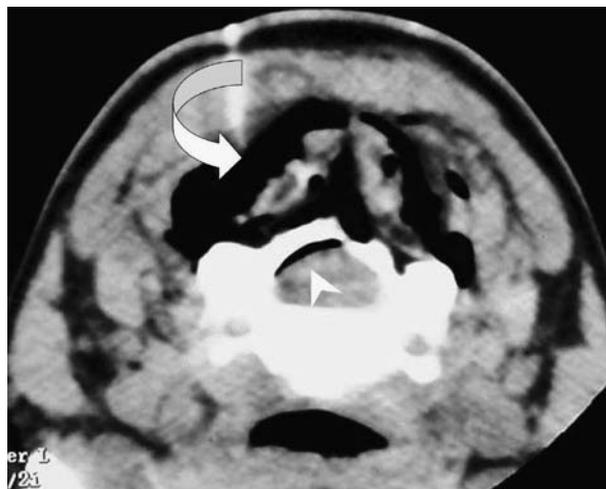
Images in a patient with cervical type of spondylosis. After paraspinal injection of 10 ml 40 μ g/ml ozone, prostrate CT scan shows ozone distributed into the paraspinal tissue (white curved arrow) and posterior peridural space (white arrowhead).
